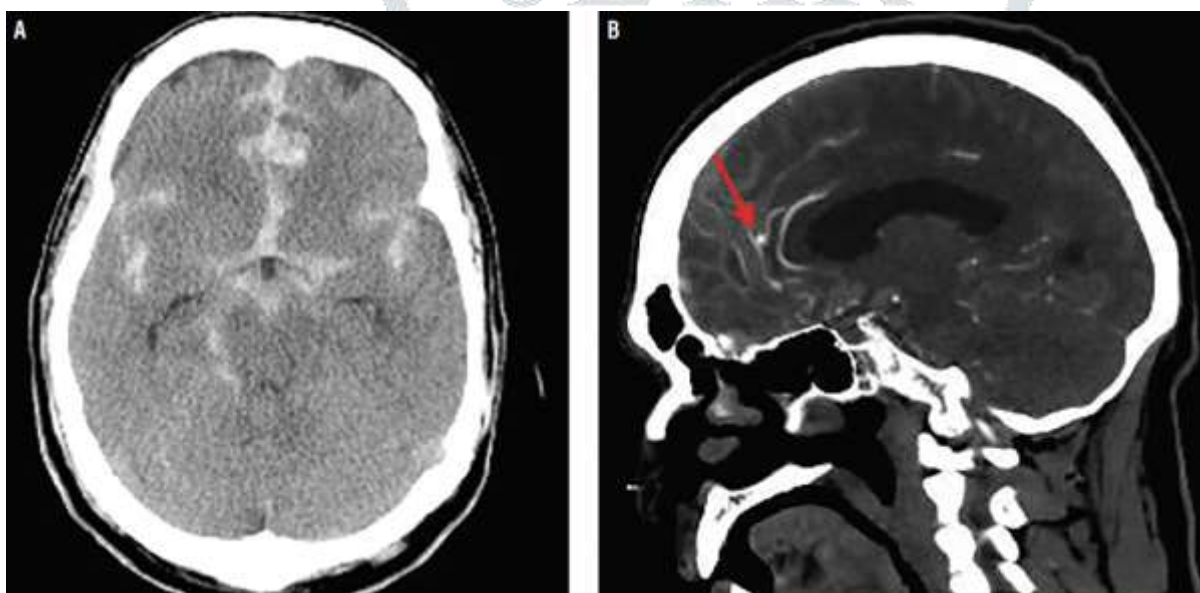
Head CT (A) demonstrates diffuse subarachnoid hemorrhage at the time of hospital admission with CT angiogram (B) showing a 5-mm ruptured pericallosal artery aneurysm (arrow).
